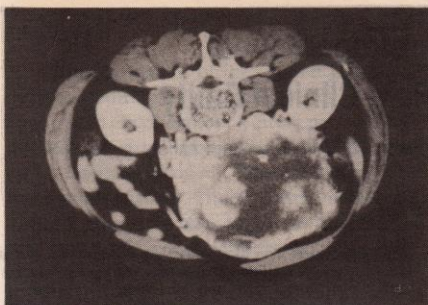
CT scan showing a large tumor
